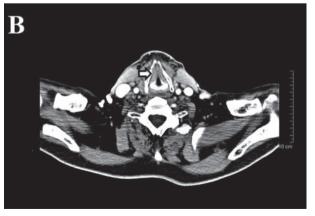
Computed tomography of the neck after two courses of everolimus. Stabilization of the metastatic lesions.
